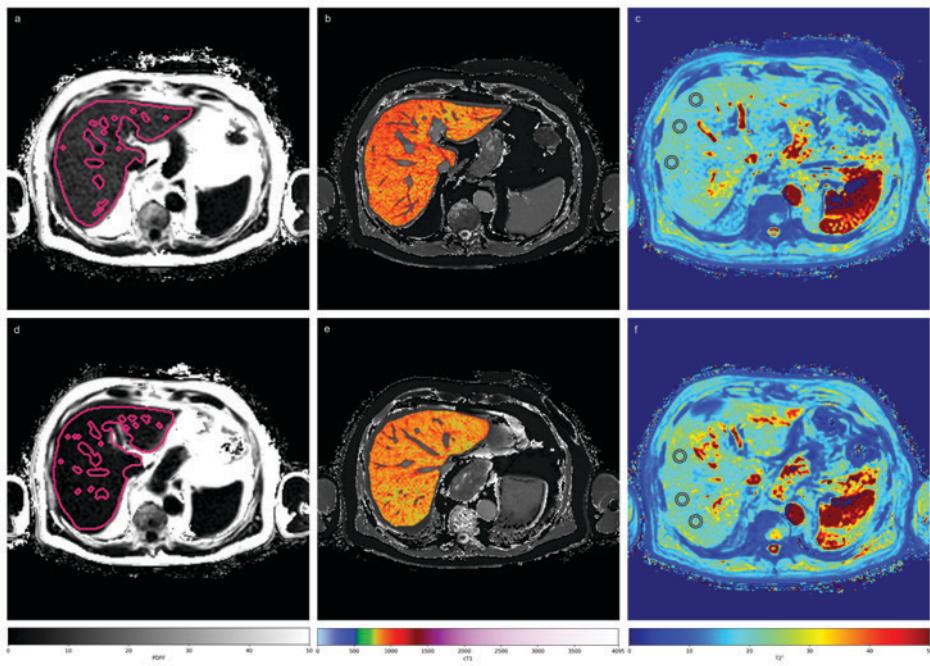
Example of MRI images after analysis with LiverMultiScan software (Perspectum Ltd., Oxford, United Kingdom).
